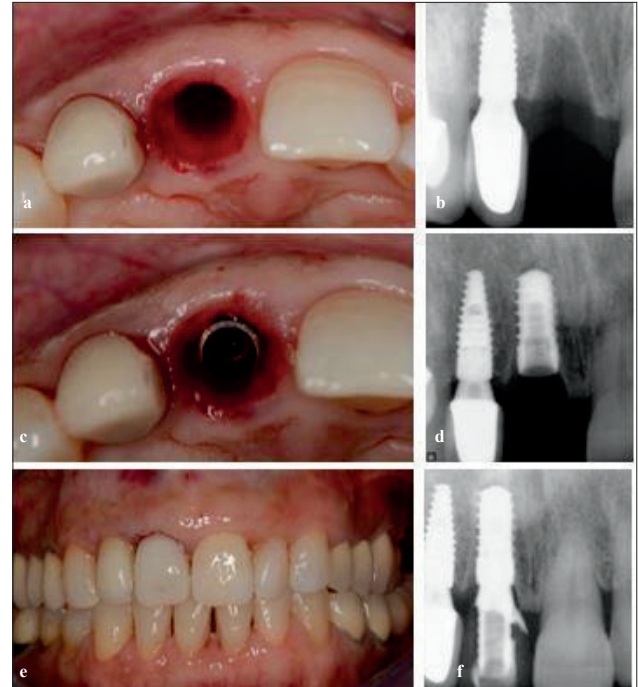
(a) occlusal view showing the alveolar socket after atraumatic extraction of tooth #11; (b) periapical radiographic image presenting the alveolar socket after atraumatic extraction of tooth #11; (c) occlusal view of the implant after its placement; (d) periapical radiographic image of the implant on site #11, note the ideal mesio-distal position and axis; (e) frontal view showing the polished provisional crown. Note the xenograft particles on the gingival margin of the provisional restoration; (f) periapical radiographic image presenting the immediate implant placement with immediate provisionalization.
